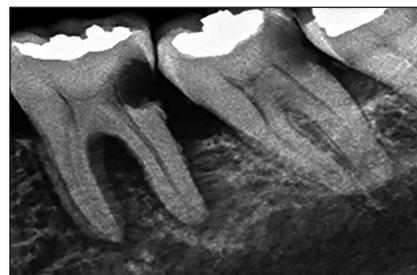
Pre operative radiograph Pre operative clinical view
